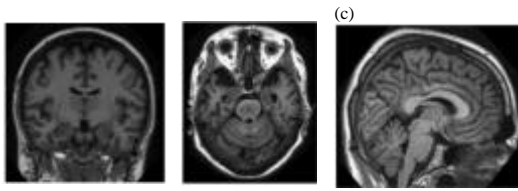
Slice types in MRI image (OASIS database sets):
